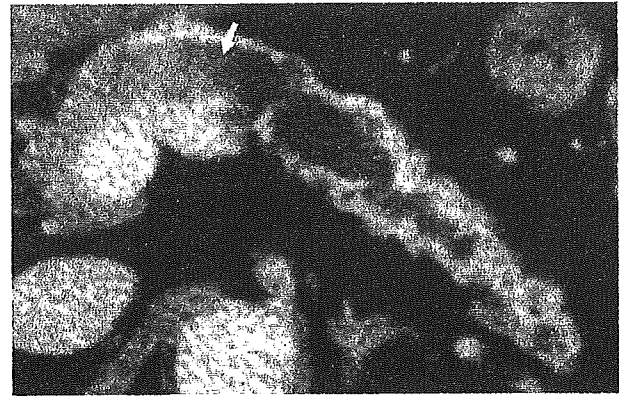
Computed tomogram showing a markedly dilated main pancreatic duct in a patient with a main duct IPMN with a mural nodule in the body of the pancreas (arrow).
